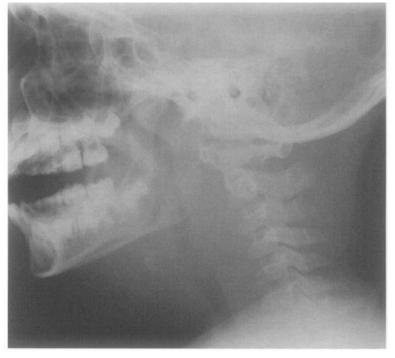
Lateral neck radiograph showing soft tissue swelling anterior and posterior to the trachea.
